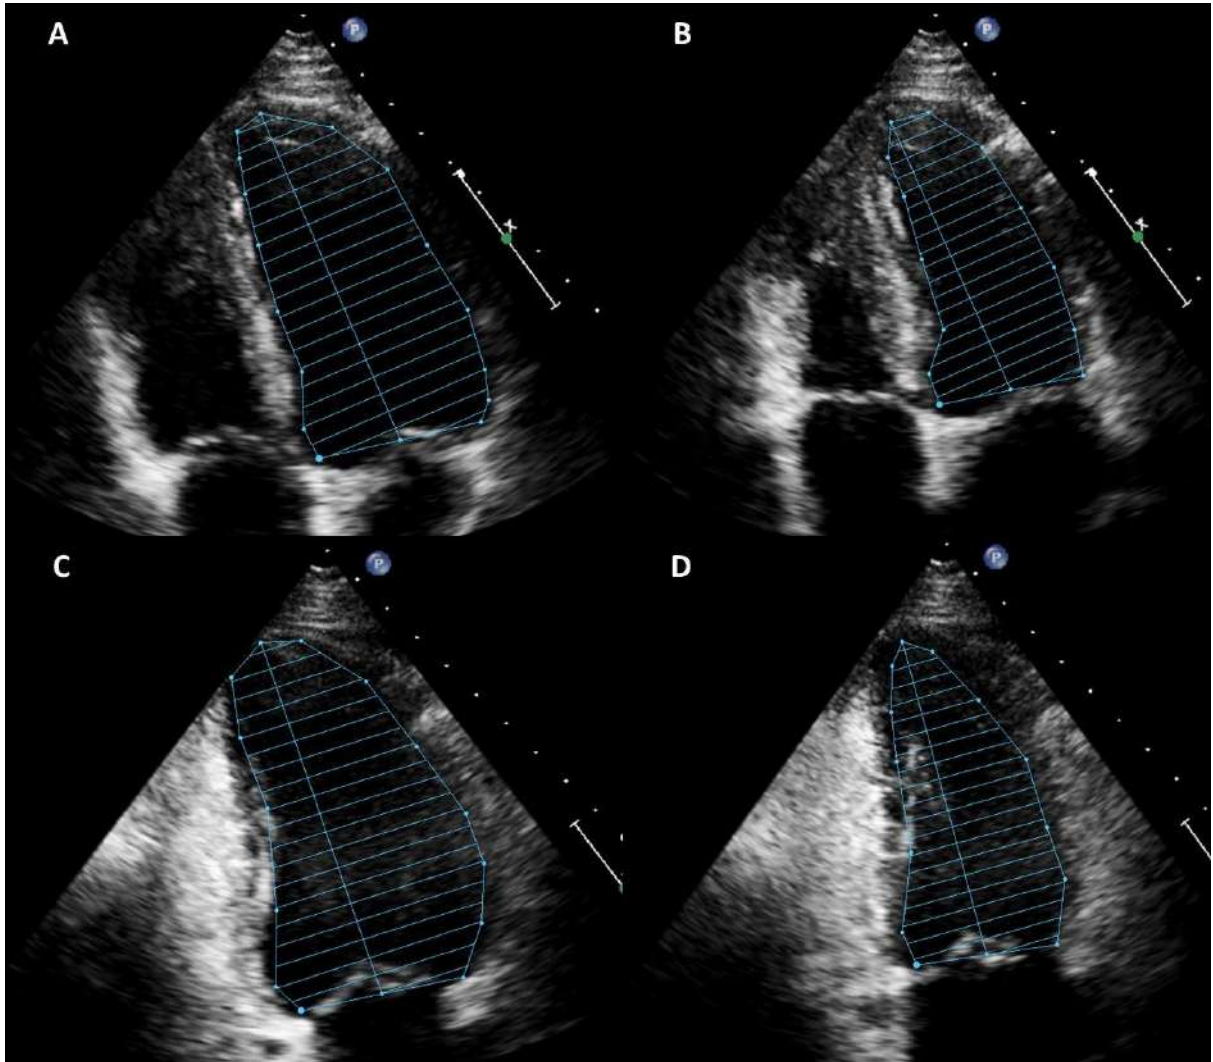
Calculation of left ventricular ejection fraction by Simpson's biplane method. A – Apical 4-chamber end-diastolic volume. B – Apical 4-chamber end-systolic volume. C – Apical 2-chamber end-diastolic volume. D – Apical 2-chamber end-systolic volume.
